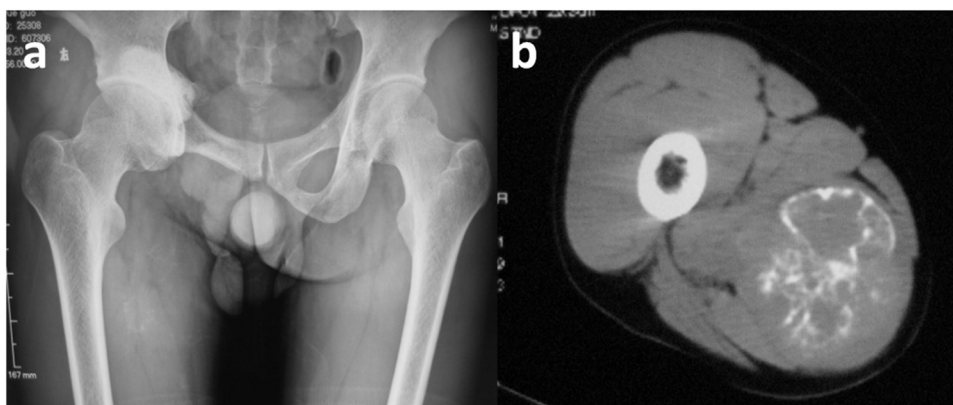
A 37-year-old male patient with giant cell tumor in the right ischium. (a–b) A centrally located ossification could be observed on both plain radiography and CT scan at the 9th month after surgery.
